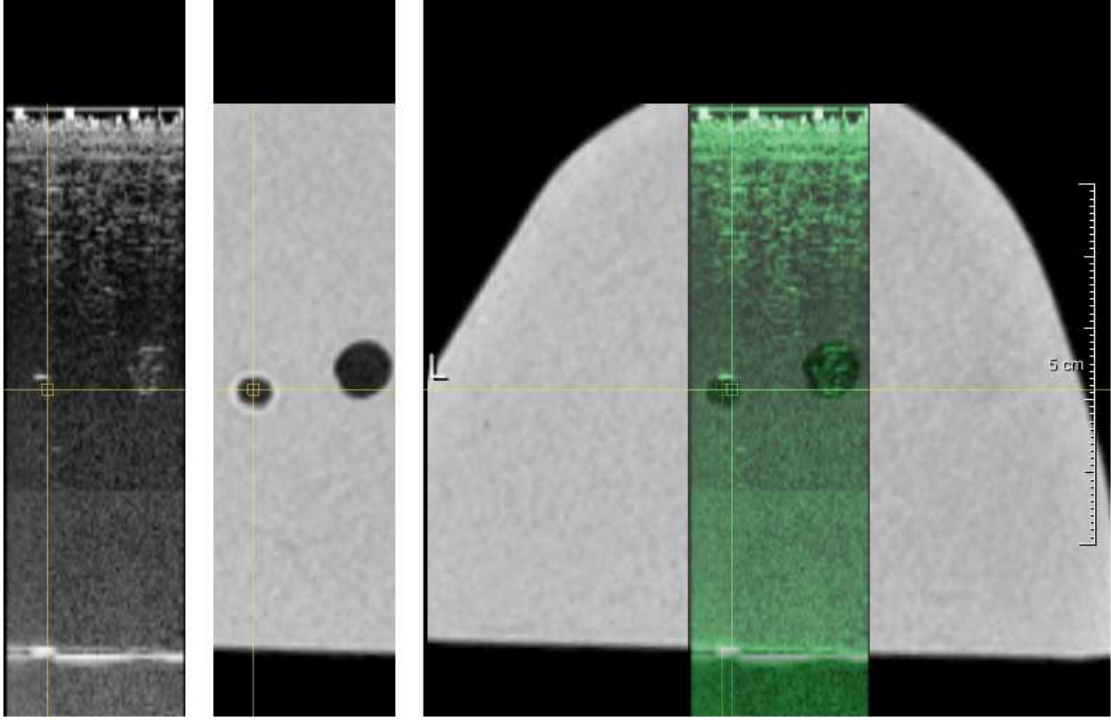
US-MRI correspondence example. (Left to right) current US 2D image; corresponding MRI slice with the same extents as the current US 2D image; overlay of the current US 2D image on the full corresponding MRI slice. (This figure originally appeared in [Kocev et al. \(2014\)](#). ©Eurographics Association 2014. Reproduced by kind permission of the Eurographics Association.)
